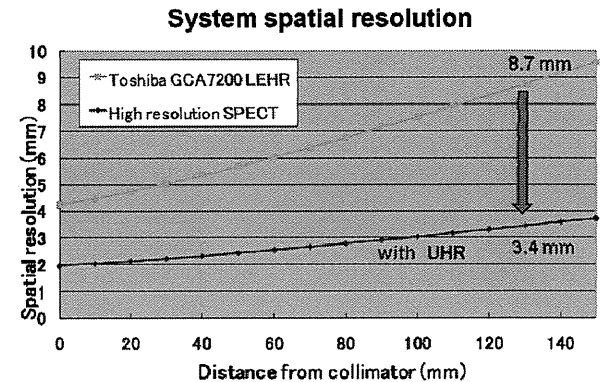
The theoretical system resolutions of high-resolution SPECT system based on our conceptual design and Toshiba SPECT GCA 7200 with LEHR collimator.
